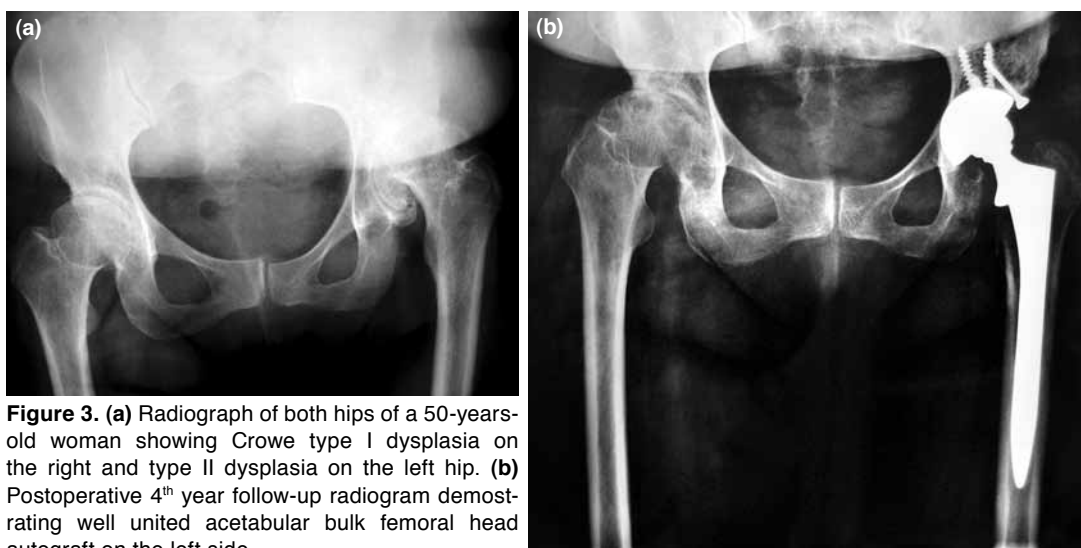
(a) Radiograph of both hips of a 50-years-old woman showing Crowe type I dysplasia on the right and type II dysplasia on the left hip. (b) Postoperative 4th year follow-up radiogram demonstrating well united acetabular bulk femoral head autograft on the left side.
